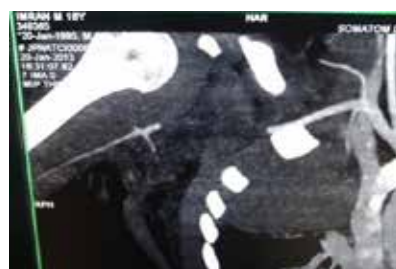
(CT Angiography on day of injury)
